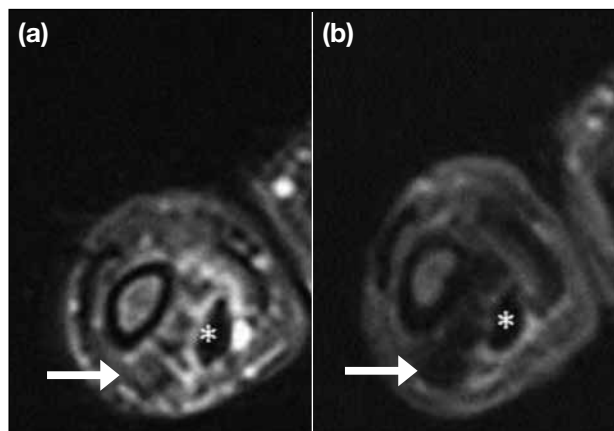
Giant cell tumour of tendon sheath in a 48-year-old woman who presented with right thumb nodularity: (a) T2-weighted fat-saturated axial magnetic resonance image showing multi-lobulated lesion (arrow) at the volar aspect of the thumb at the interphalangeal level with intermediate signal intensity. It is seen adjacent to and partially encasing the flexor tendon (asterisk). (b) Gradient echo axial magnetic resonance image showing blooming artefacts with internal marked hypointense signal.
